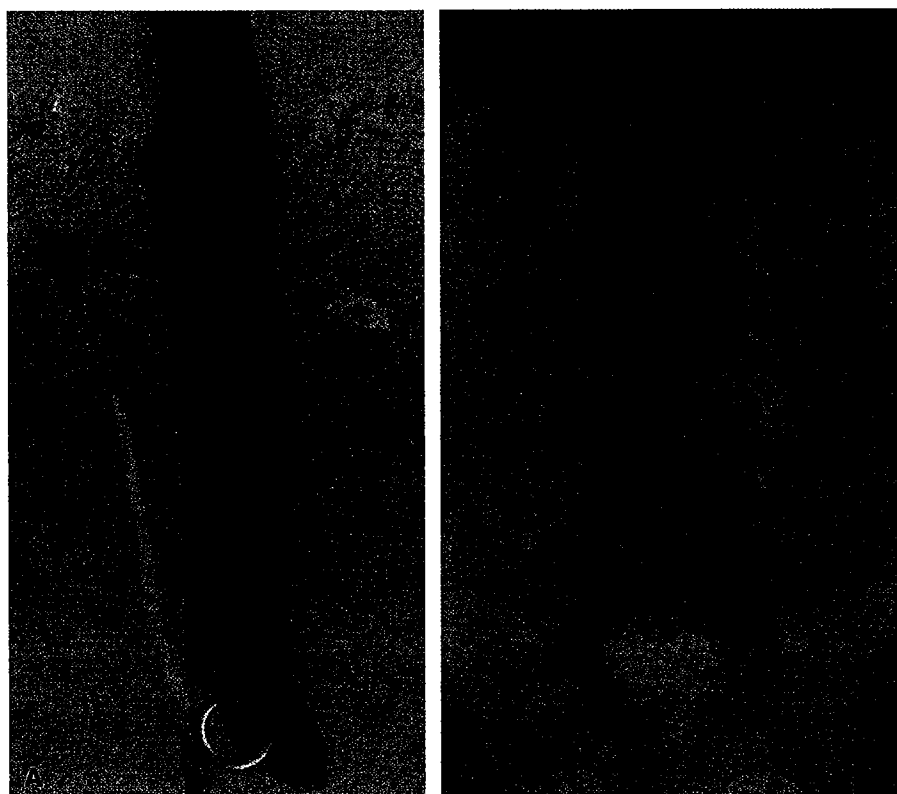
A Inferior vena cavography through the right internal jugular vein shows normal caliber and patency of IVC. B Control digital roentgenogram shows the proper location of the temporary vena cava filter.
